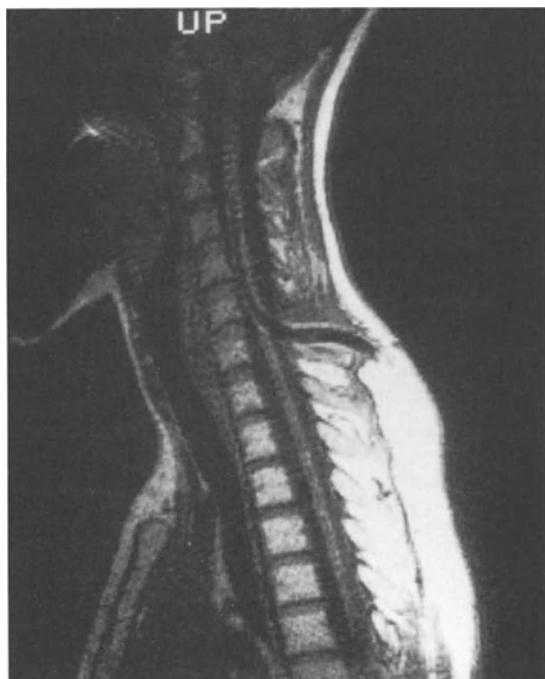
Postoperative MRI study 2 years following SPL shunting showing excellent result with complete collapse of the intramedullary cavitation
